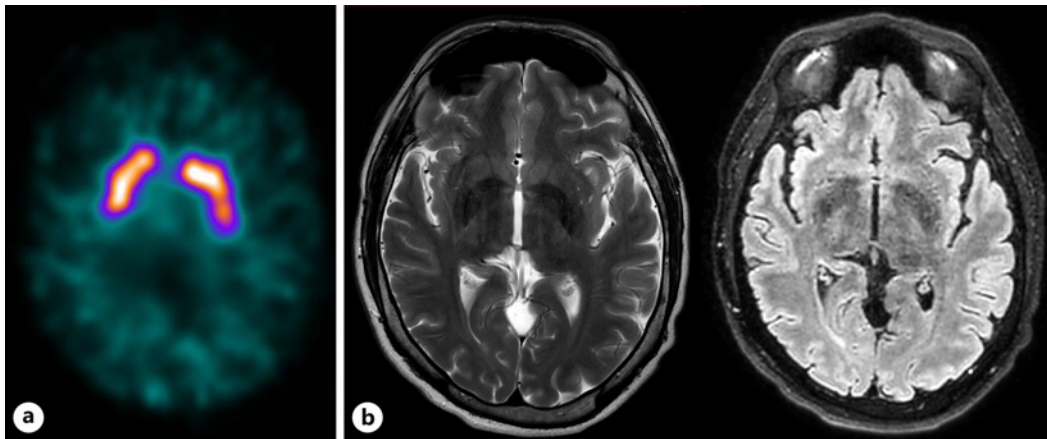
Patient imaging results. a DaT SPECT with [123 I]FP-CIT showed a visual distribution of the radiotracer within the striatum within the norms. b Brain MRI. Axial T2 and FLAIR images show the absence of brain lesions, leukoencephalopathy, or cerebral atrophy.
